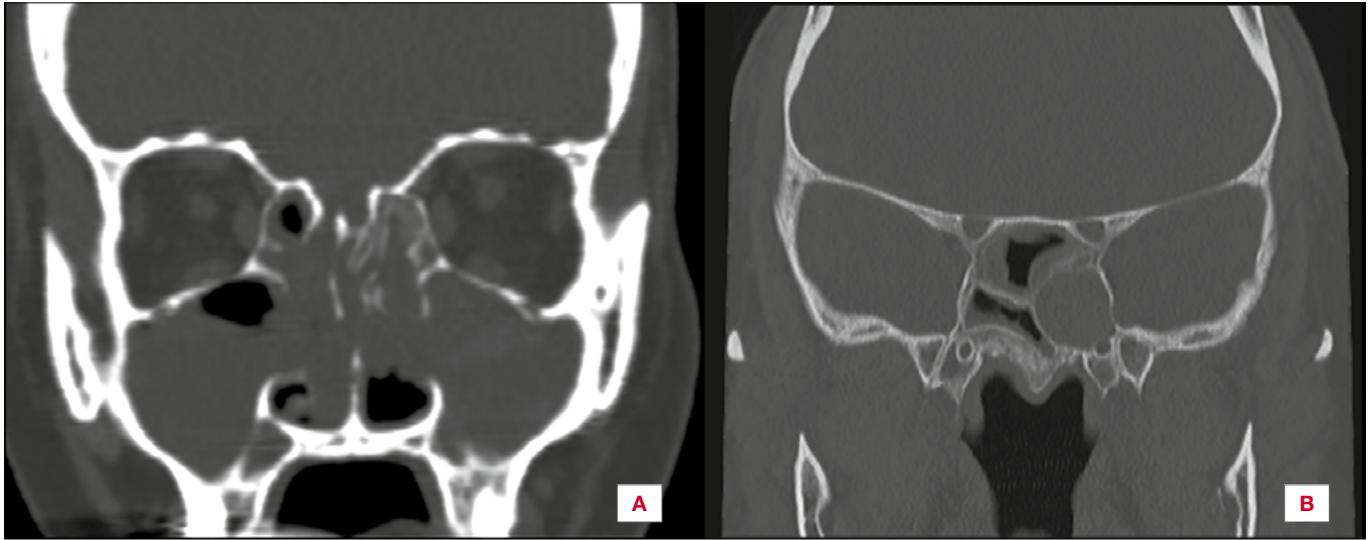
A) CT scan of a patient with CRSwNP at 3 years from the last endoscopic sinus surgery. CT shows bone discontinuation at the level of the right cribriform plate in the suspicion of CSF leakage or meningoencephalocele; B) CT scan shows a suspected left sphenoidal sinus mucocoele in a patient with CRSwNP on biologic therapy. The patient had already undergone 2 endoscopic sinus surgeries before biologic treatment.
